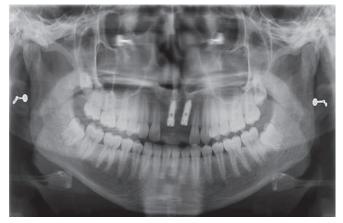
Implant placement orthopantomogram
